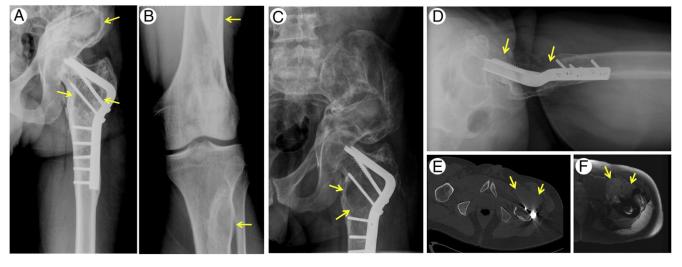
Anteroposterior radiographs of the left hip (A) and left knee (B), taken 9 years before presentation, demonstrating the classic findings of polyostotic FD with bubbly mixed lytic and sclerotic, slightly expansile lesions with central ground glass attenuation in the left innominate bone, left proximal and distal femur, and within the left proximal tibia (arrows). In addition, noted are postoperative changes in the proximal left femur from prior femoral osteotomy with blade-plate and screw fixation. Anteroposterior (C) and lateral (D) radiographs of the left hip at presentation demonstrate changes of polyostotic FD in the left innominate bone and proximal femur with a new lytic destructive lesion in the left proximal femoral intertrochanteric region representing a change since the prior radiographs that is suspicious for malignant degeneration of FD (arrows). Axial computed tomography (E) and axial postcontrast fat-saturated T1-weighted MRI images (F) of the left proximal femur demonstrate an aggressive mass with cortical destruction anteriorly and a large enhancing soft tissue mass (arrows).
